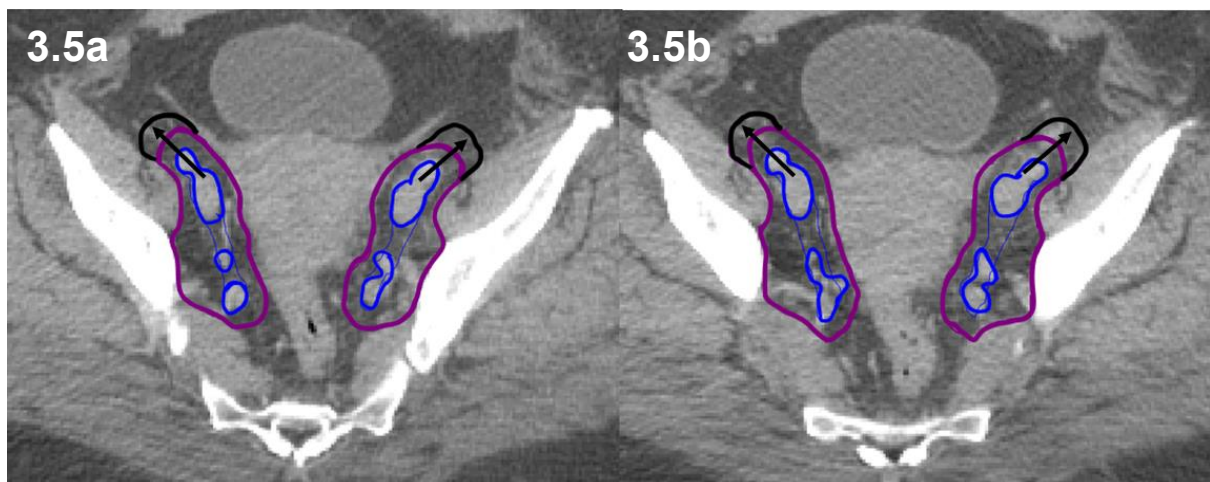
Transverse CT at the level of the internal and external iliac vessels showing extension antero-laterally (arrowed) along the iliopsoas muscle to include the lateral external iliac nodes.
